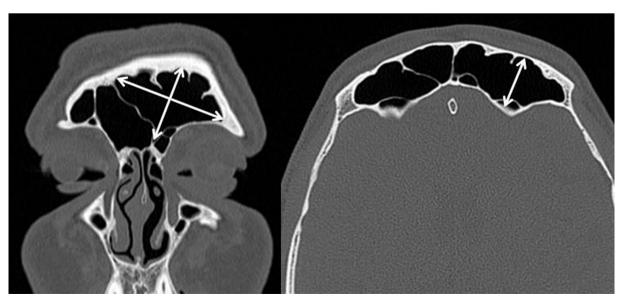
Coronal and axial paranasal measurements made over the left frontal sinus computed tomographic scan.
